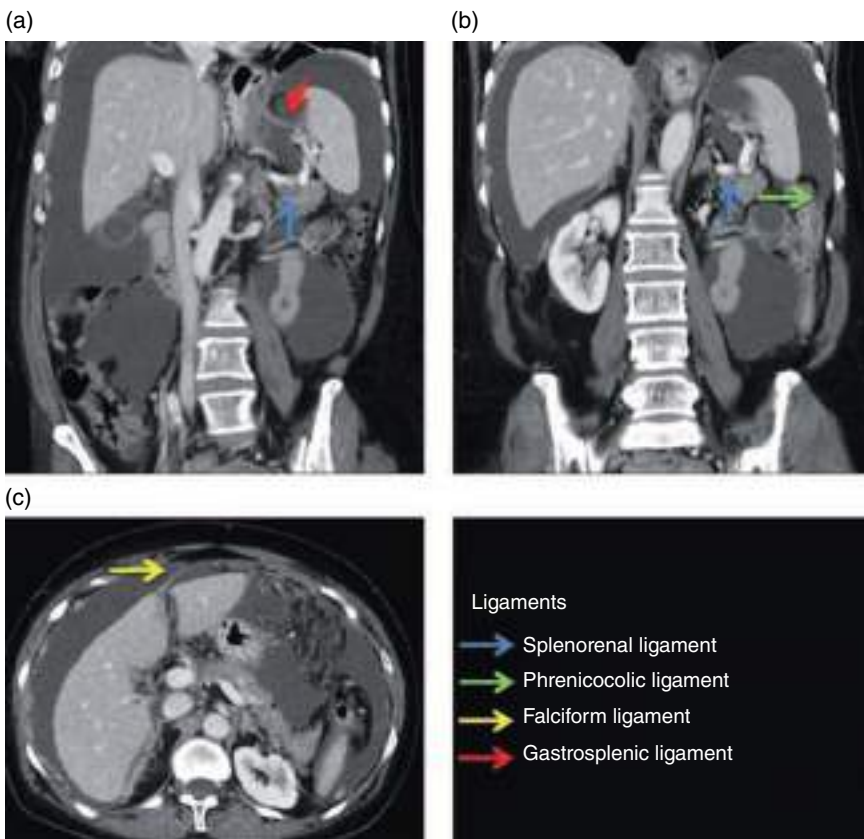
Peritoneal ligaments in patient with ascites due to peritoneal carcinomatosis secondary to ovarian tumor. (a, b) Coronal contrast-enhanced MPR CT image (portal venous phase). (c) Axial contrast-enhanced CT image (portal venous phase).
